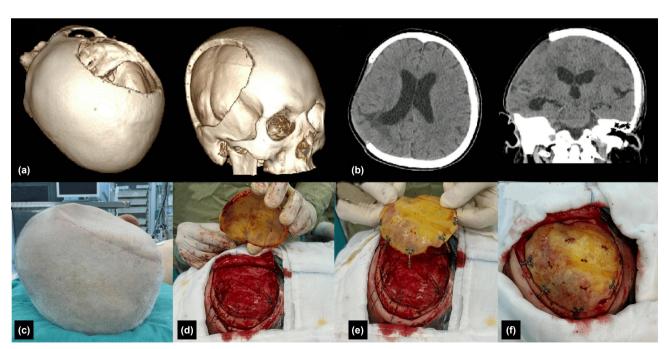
Autologous cranioplasty. a) 3D images of the patient's cranial defect area. b) Computed tomography (CT) images showing the craniectomy site before cranioplasty. c) Cranial defect area with previous incision scars. d) Autologous bone graft and defect area. e) Attachment of the dura to the bone graft using silk suspension sutures. f) Fixation of the bone graft with titanium plates and screws.
